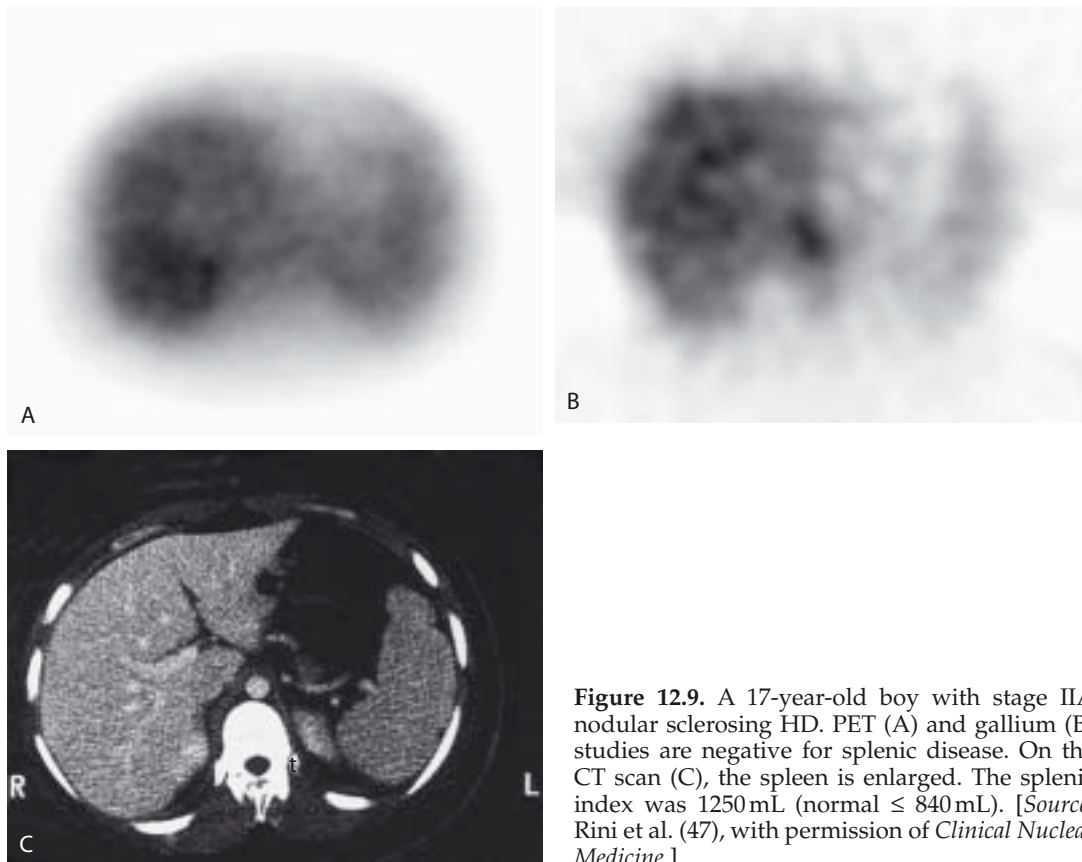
A 17-year-old boy with stage IIA nodular sclerosing HD. PET (A) and gallium (B) studies are negative for splenic disease. On the CT scan (C), the spleen is enlarged. The splenic index was 1250 mL (normal ≤ 840 mL). [Source: Rini et al. (47), with permission of *Clinical Nuclear Medicine*.]
